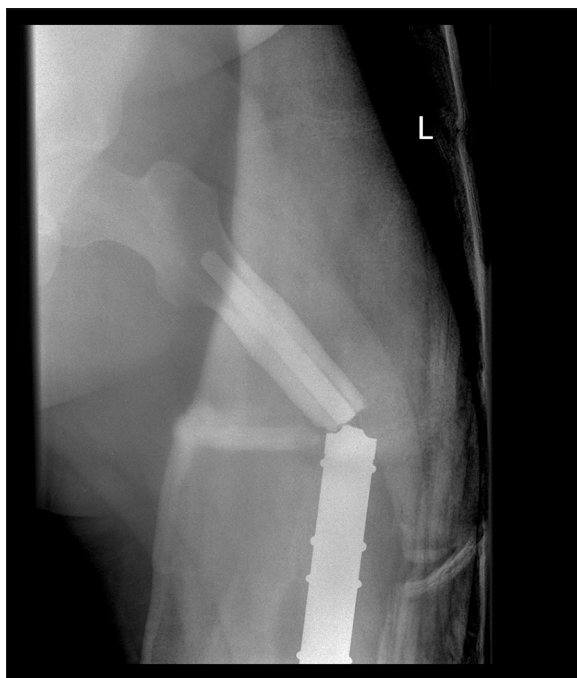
16-year-old boy with femoral osteosarcoma six years after implantation of endoprosthesis presenting after trauma. X-ray: fracture of the prosthesis.
